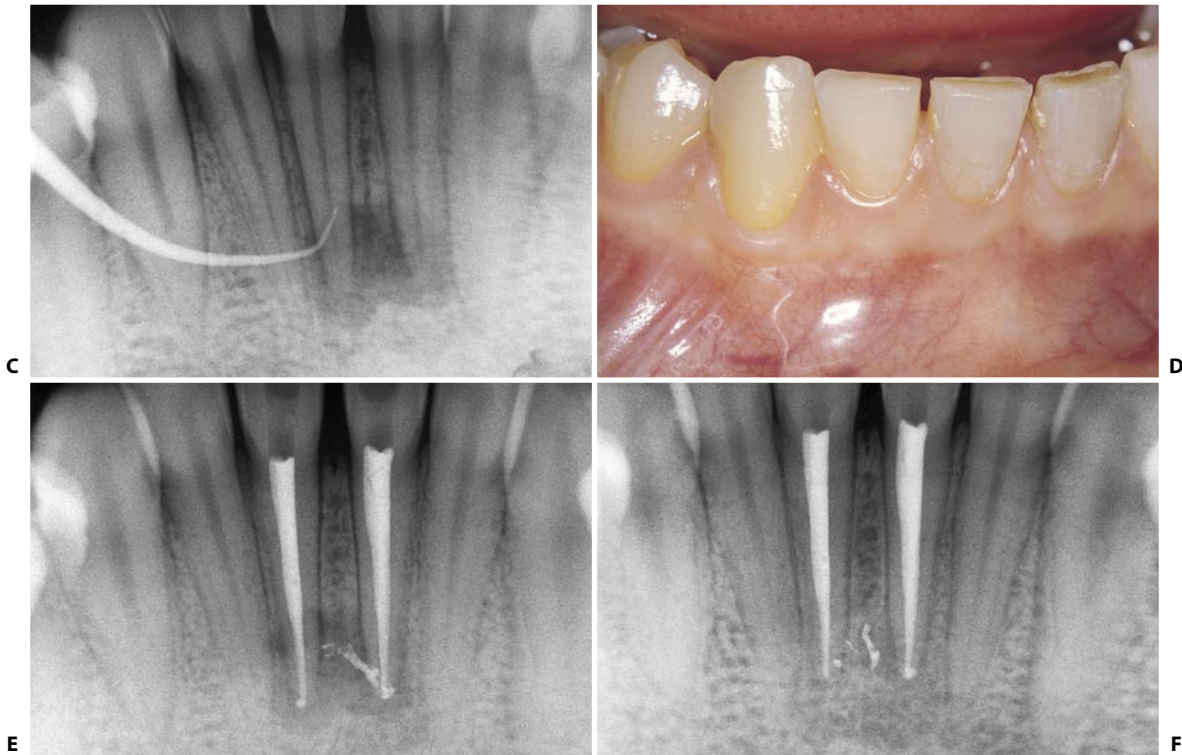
(continued) C. Deeper insertion of the gutta-percha cone finally identifies the two lower central incisors as the diseased teeth. Both respond negatively to the various vitality tests. D. One week after cleaning and shaping, the fistula has closed. E. Postoperative radiograph. F. Two year later.
